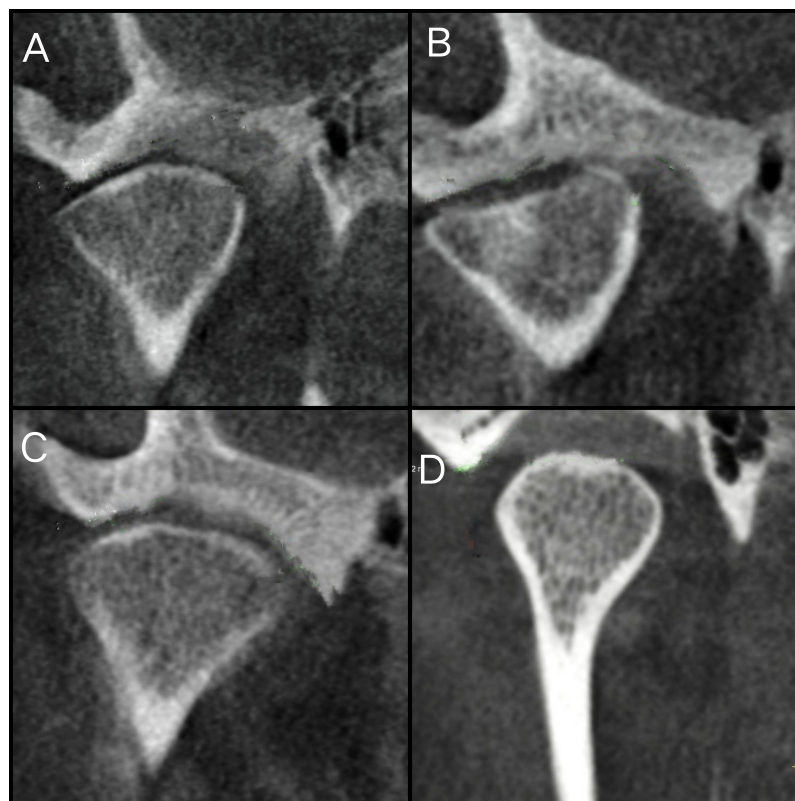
Various shapes of the condyle in the coronal view of CBCT. (A). Round (B). Trapezoidal (C). Triangular (D). Oval.
